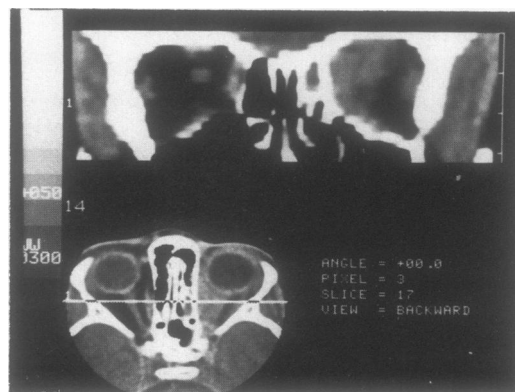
Computed tomography of orbits, sphenoid and ethmoid air sinuses, indicating retro-orbital soft tissue mass on left with infiltration of sinuses.
